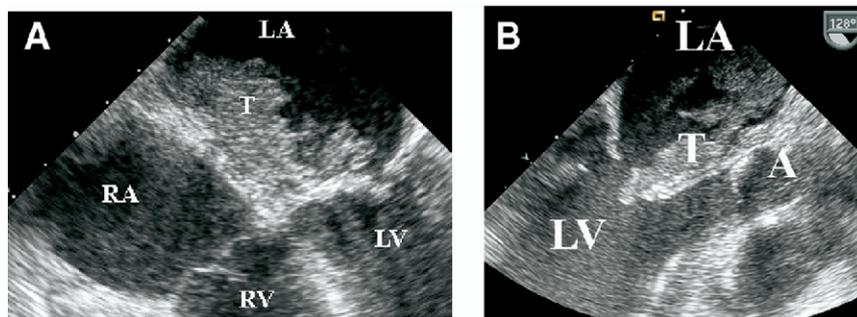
A, Two-dimensional transesophageal echocardiography revealed large left atrial (LA) tumor (T) with multiple highly mobile papillary projections, infiltrating interatrial septum and LA appendage. B, T extends along entire atrial surface of anterior leaflet of mitral valve, with diastolic prolapse into mitral funnel. There was moderate obstruction of mitral valve orifice and mild valvular regurgitation (not shown). A, Aorta; LV, left ventricle; RV, right ventricle.
